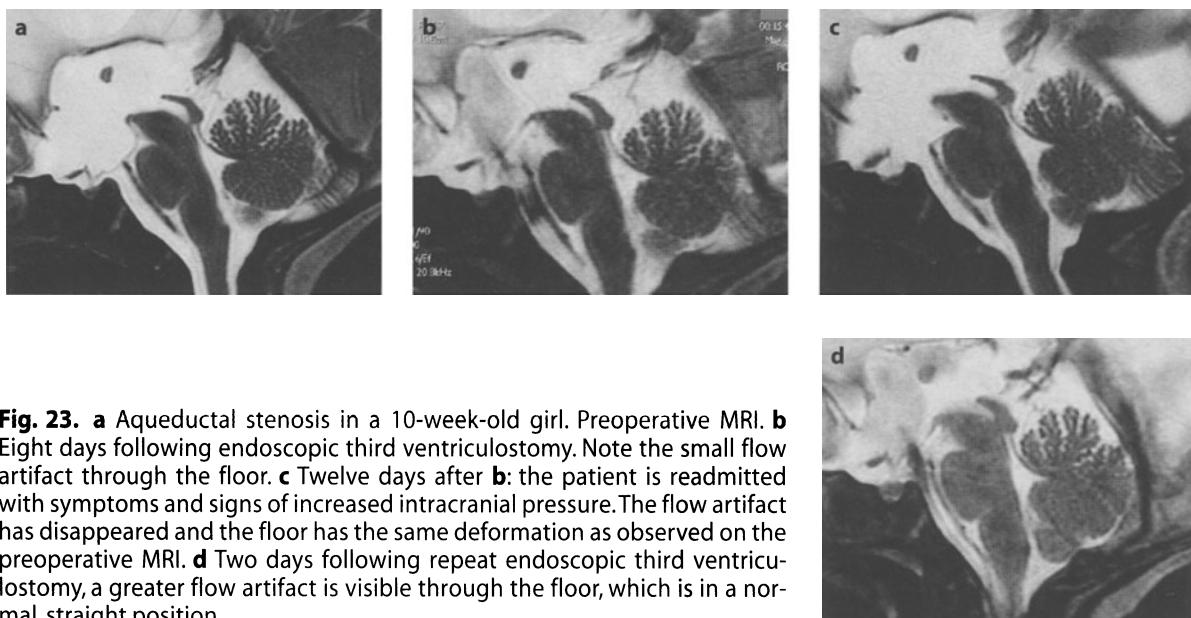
a Aqueductal stenosis in a 10-week-old girl. Preoperative MRI. b Eight days following endoscopic third ventriculostomy. Note the small flow artifact through the floor. c Twelve days after b: the patient is readmitted with symptoms and signs of increased intracranial pressure. The flow artifact has disappeared and the floor has the same deformation as observed on the preoperative MRI. d Two days following repeat endoscopic third ventriculostomy, a greater flow artifact is visible through the floor, which is in a normal, straight position
